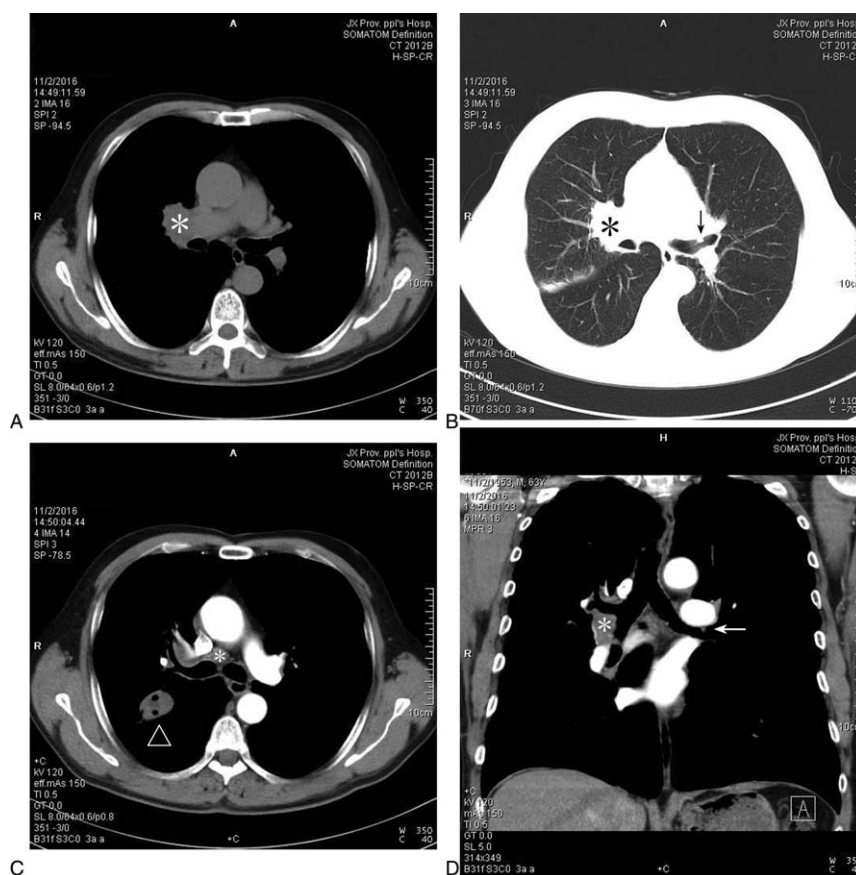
Chest CT revealed a crumby-shaped soft tissue density in the upper right lobe of the right lung (arrows), swollen lymph nodes in the hilar and mediastinum (asterisk), and a “neoplasm,” with a smooth surface and normal mucosa breaking into the upper left bronchus in the left lung (arrowheads) (shown in A, B, C and D).
